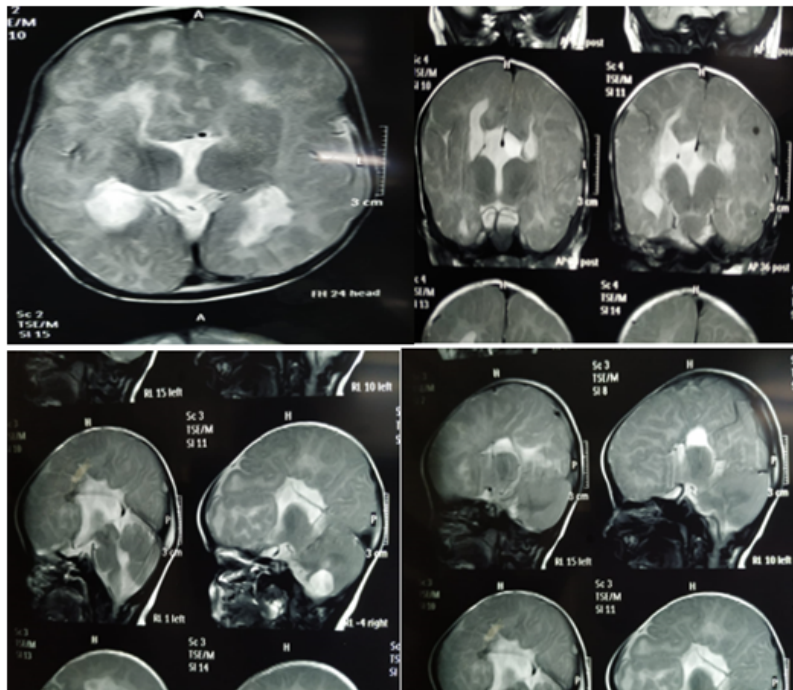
Mri Brain Showing Hypomyelination and Absence of Corpus Callosum; A,B: Sagittal T1-weighted MRI Brain; CD: Axial T1-weighted MRI.
